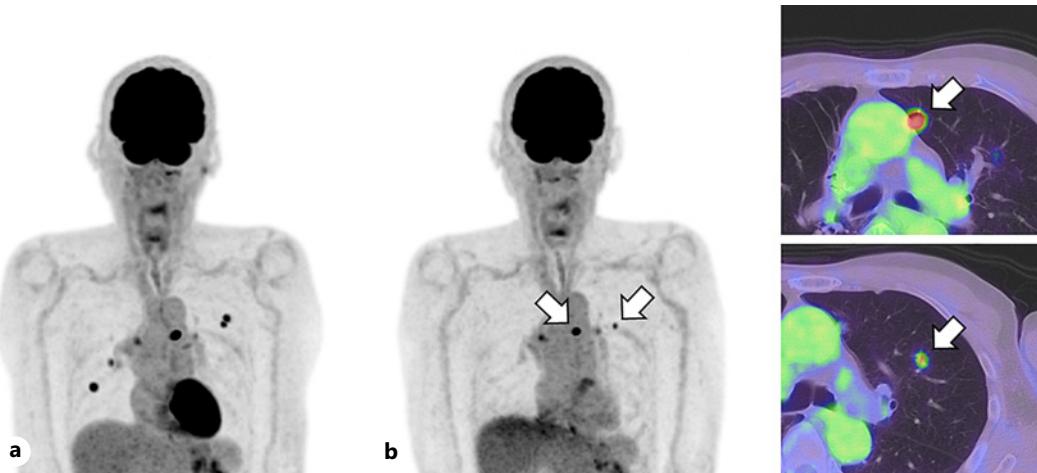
18-fluoro-deoxyglucose positron emission tomography (FDG-PET) findings obtained 5 months after chemoradiotherapy. a The findings indicated that multiple metastases were observed in both lungs. b FDG-PET and computed tomography (CT)-fused images obtained at 6 months after nivolumab initiation indicated that multiple lung metastases completely regressed during treatment, although two recurred in the left upper lobe (arrow).
